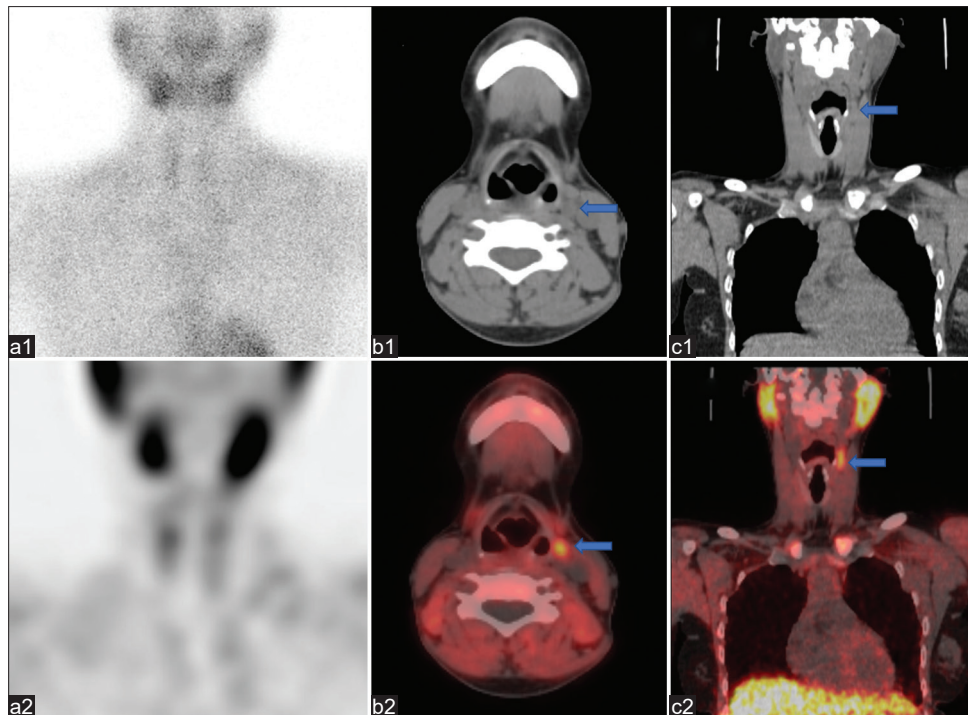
^{99m}Tc-SestaMIBI scintigraphy planar (a1) and SPECT (a2) images reveal a negative scan and ¹⁸F-fluorocholine PET/CT axial (b1 and 2) and coronal (c1 and 2) images reveal a soft-tissue density lesion (blue arrow marked), starting posterior to the left submandibular gland and extending from lateral to the left pyriform fossa up to level of left lamina of thyroid cartilage just medial to left sternocleidomastoid muscle with increased tracer uptake. PET/CT: Positron emission tomography/computed tomography, SPECT: Single-photon emission computed tomography
